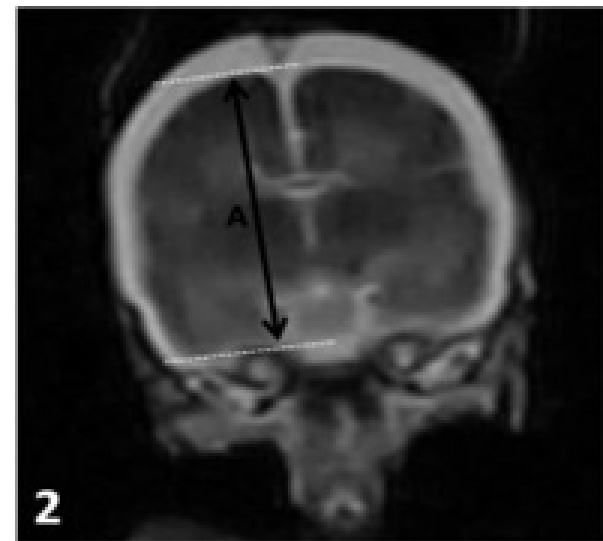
27 weeks of gestation age. coronal cranium MR image obtained with T2-weighted sequence in a male fetus. A. Right hemisphere cerebri height.
